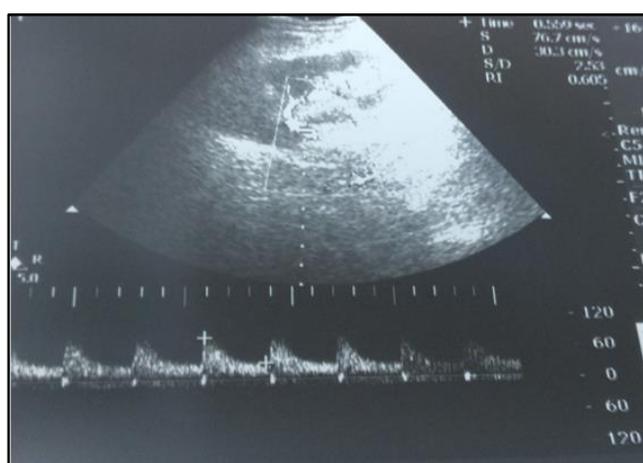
Doppler US Showing Normal Resistive Index of a Transplanted Kidney (RI-0.6)
